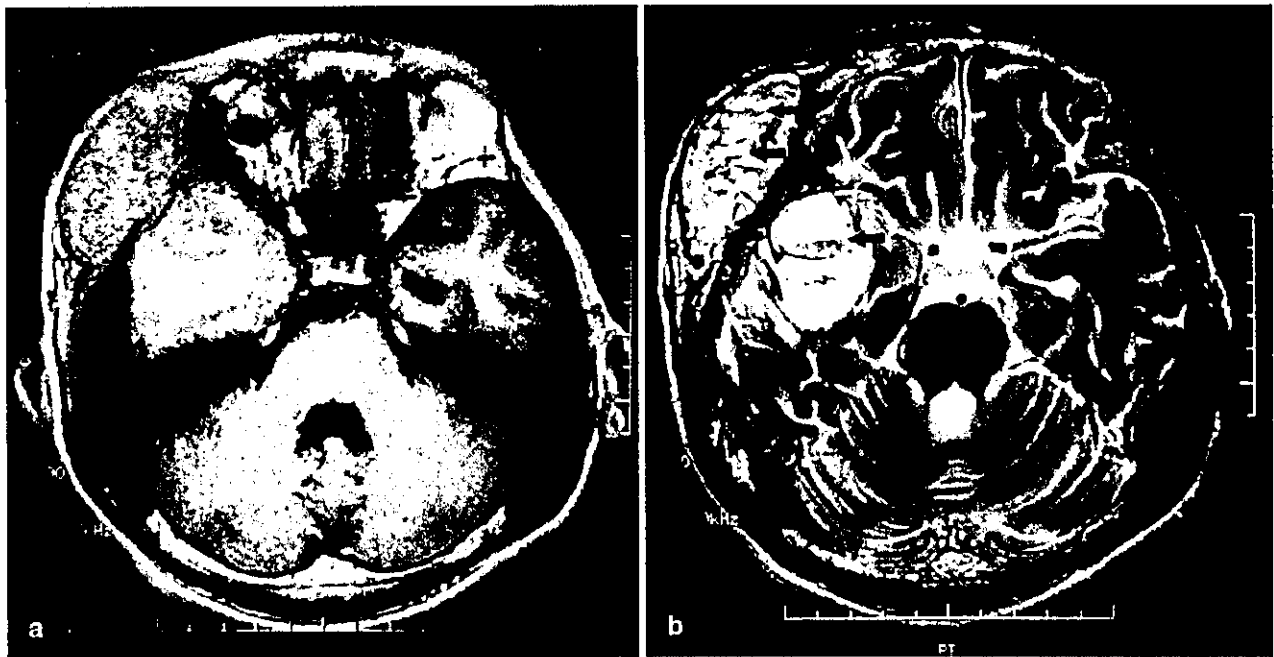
a Axial T1-weighted magnetic resonance (MR) image (TR/TE: 440/7.3 ms) showed a mass of iso signal intensity relative to white matter. Focal subarachnoid hemorrhage corresponded to area of high signal intensity surrounding the tumor. b Axial T2-weighted
